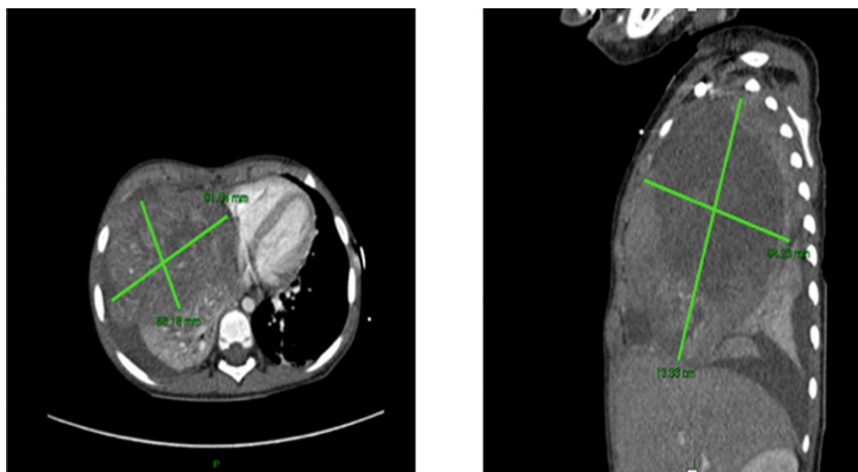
CT chest demonstrating a large right hemithorax mass, measuring 13×8x9cm, with two distinct components to the mass in Child 4. Overall mass effect resulted in moderate right to left mediastinal shift.
